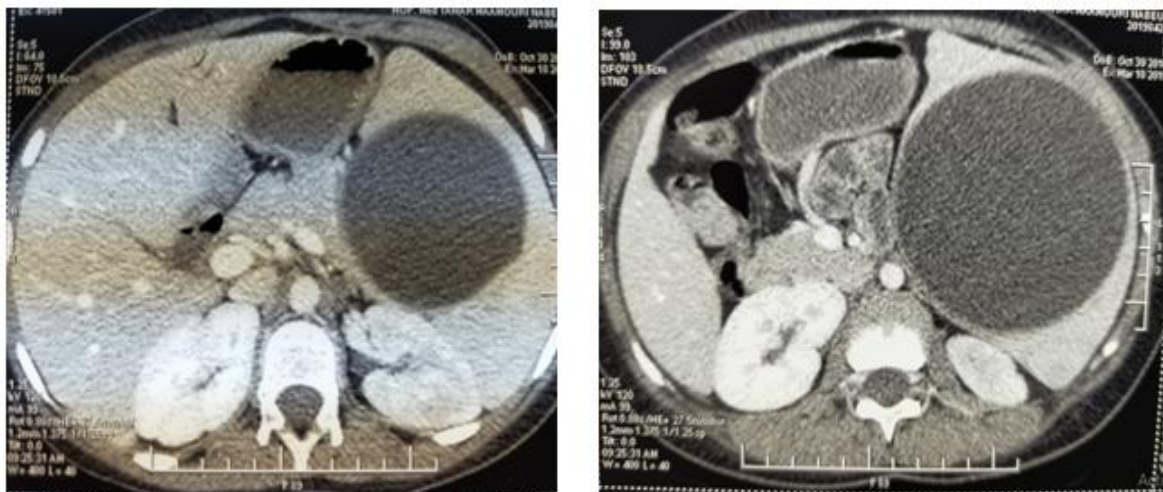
CT: A large splenic cystic mass of the spleen, suggesting an epidermoid cyst or a hydatid cyst
